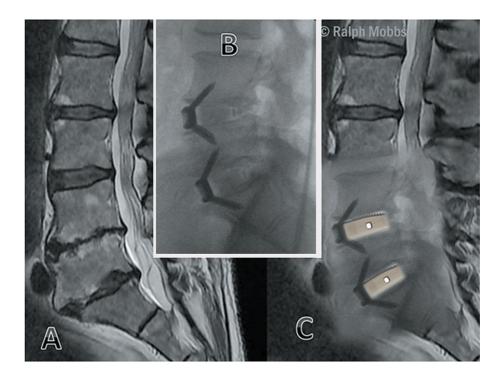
(A) MRI showing degenerative disc disease with foraminal stenosis at the L_{4-5} and L_5S_1 levels prior to ALIF surgery. (B) Post-operative X-ray with anterior interbody fusion at L_{4-5} and L_5S_1 . (C) Onlay of MRI-X-ray showing the interbody device.
